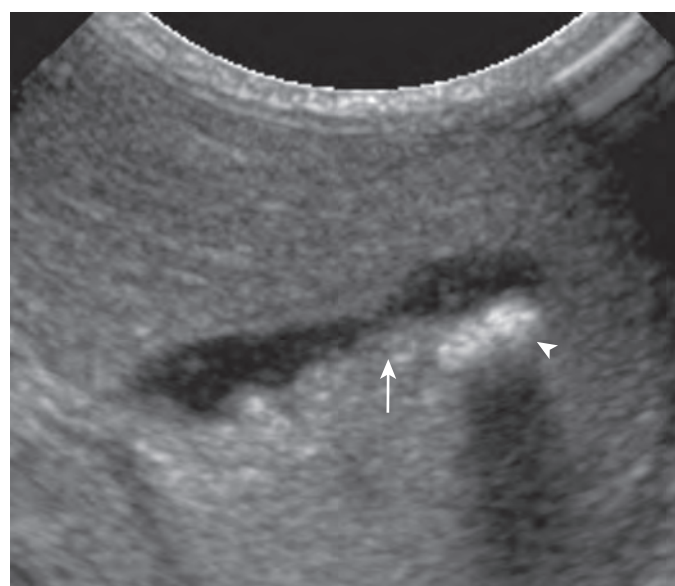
Neonatal gallstone. Ultrasound image of a 1-day-old infant (gestational age of 37 weeks) demonstrates a gallstone (arrowhead) and sludge (arrow) within the gallbladder.
